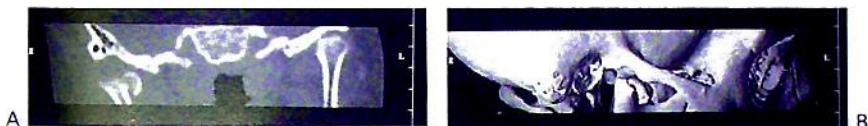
Use of computed tomographic reformatting to visualize fractures to the mandibular condyle. (A) Coronal section showing an intracapsular fracture with medial displacement of the condylar head due to the pull of medial pterygoid muscle. (B) 3-dimensional reconstruction showing the degree of displacement of the condylar head following chin-point trauma.
